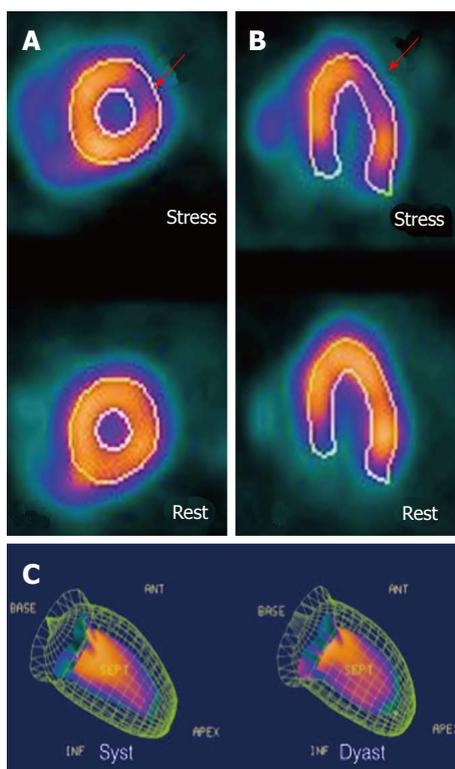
Evaluation of ischemia using single-photon emission computed tomography. A: Short axis view of the left ventricle with a perfusion defect visible after pharmacologic stress test in the anterior lateral wall (territory of the circumflex artery); B: Confirmation of the perfusion defect in the long axis view; C: Gated-single-photon emission computed tomography used to evaluate left ventricular function.
